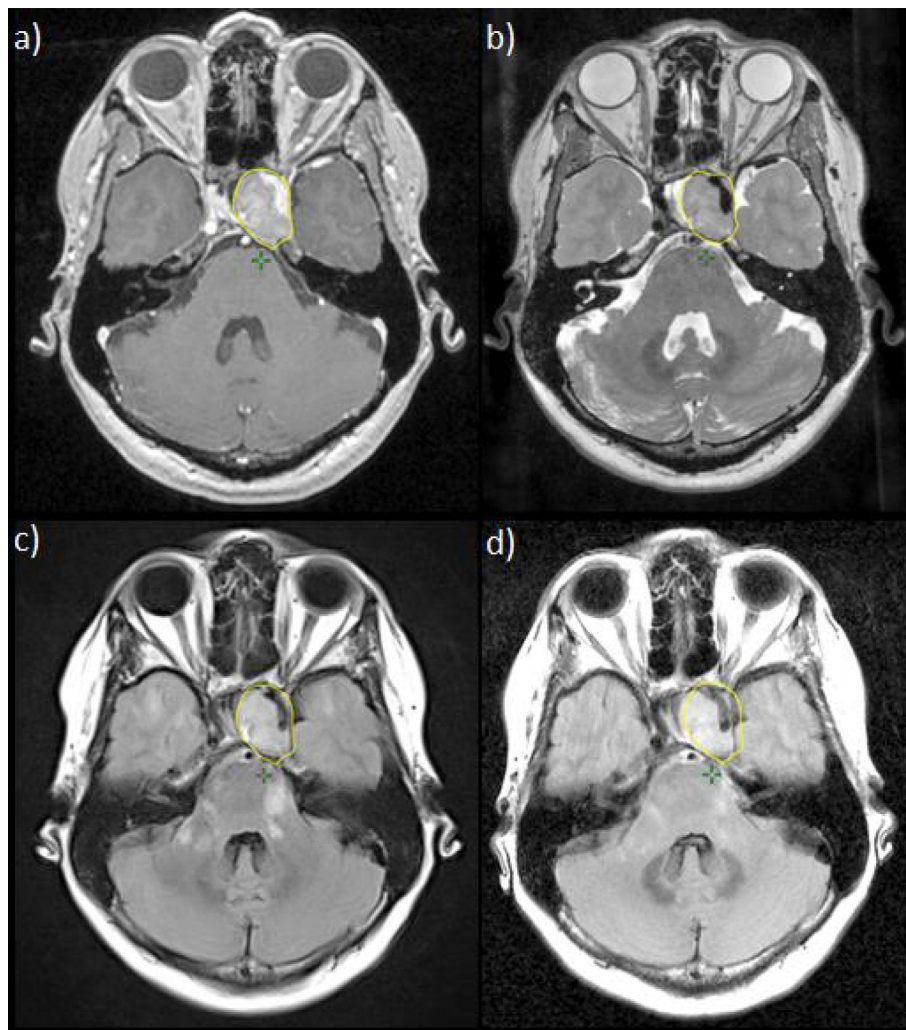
Delineation of the pituitary macroadenoma on a 3D T1 Gadolinium-enhanced (a) and T2 (b) axial brain MRI performed in March 2018. Stability of the pituitary adenoma but appearance of multiple infra and supratentorial T2 Flair hyperintense lesions, particularly in the posterior part of the brainstem and cerebellar peduncle and right Sylvian fissure, associated with discrete contrast-enhancing, on a T2 Flair axial Brain MRI performed in September 2018, i.e. 3 months after radiotherapy (c). Decrease in T2 hyperintense lesions on T2 Flair axial Brain MRI performed in November 2018 (i.e. 5 months after radiotherapy) after treatment with intravenous corticosteroids 1 g/day for 4 days (d).
